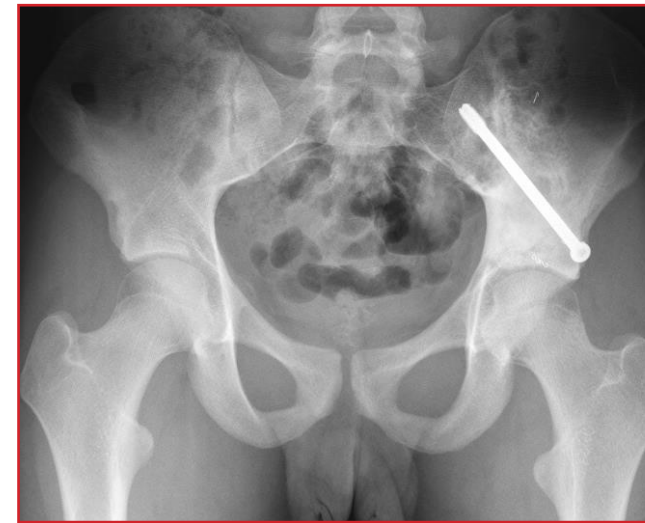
Radiograph obtained at 16 months after the third procedure shows the successful treatment of the unicameral bone cyst, with no recurrent lesion and a cannulated screw inserted in the left ilium.
